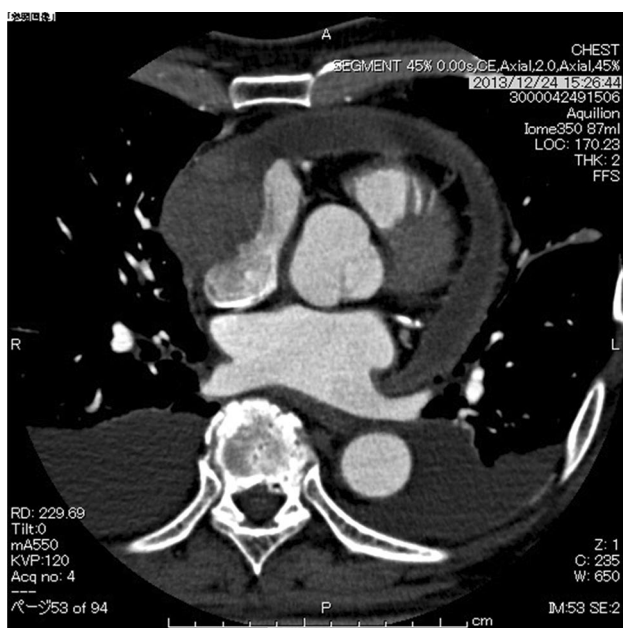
A chest computed tomography scan showing the shadow of a solid mass in the pericardial space firmly compressing the right atrium, the thickened pericardium and the bilateral pleural effusion
